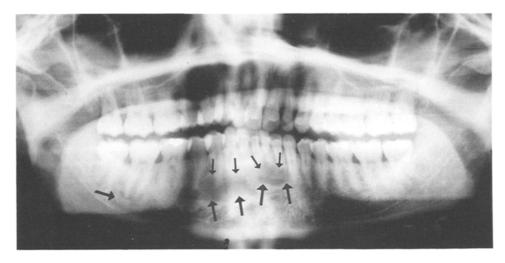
Orthopantomograph of the probands elder daughter (II-3, Fig. 3) showing periapical radio-lucent and radiodense lesions (*arrows*)
